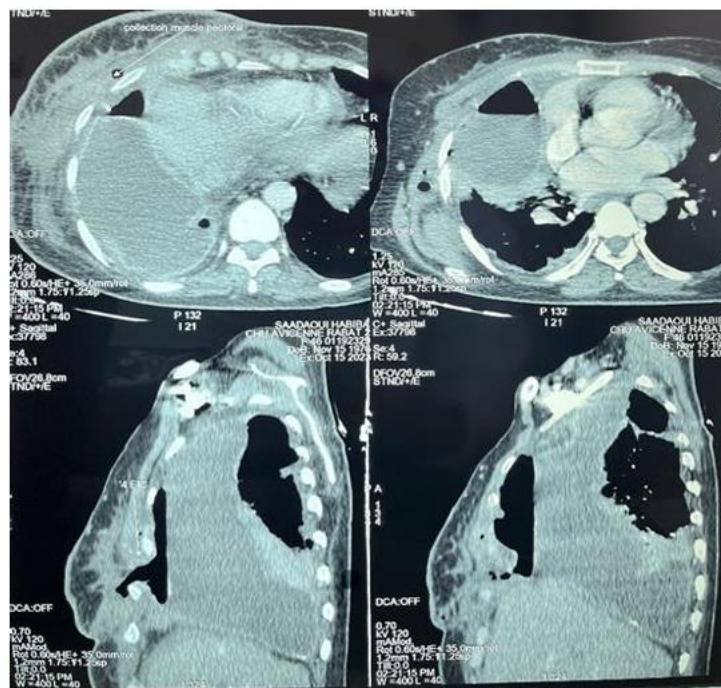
Chest CT showing large right pleural effusion with an empyema necessitans.
